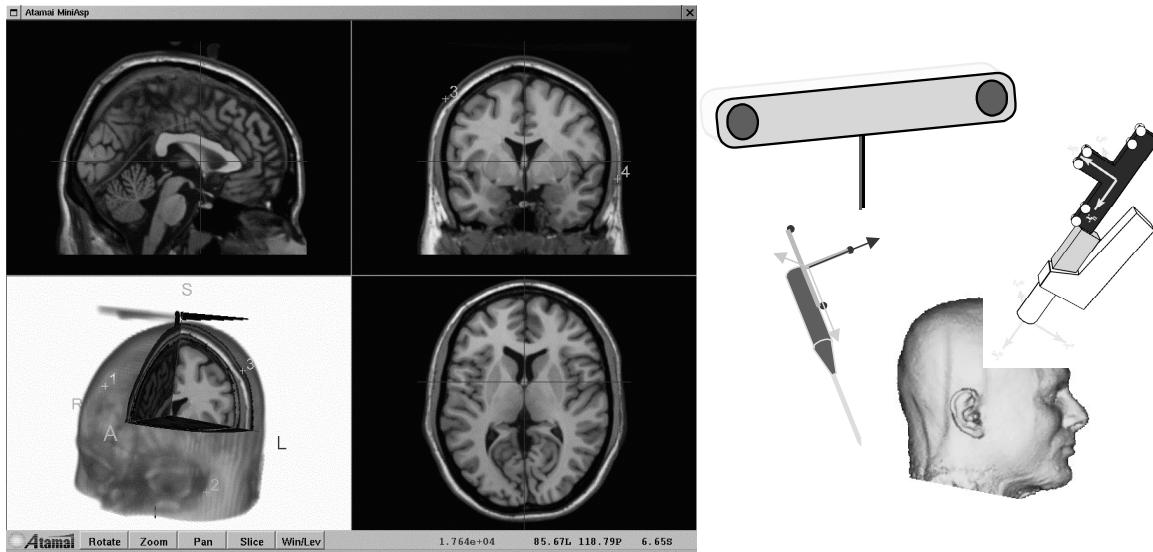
Our image-guided surgery platform. The surgical pointers and ultrasound probes are tracked with a POLARIS optical tracking system (Northern Digital Inc., Waterloo, ON, Canada) with an accuracy of 0.4 mm.
